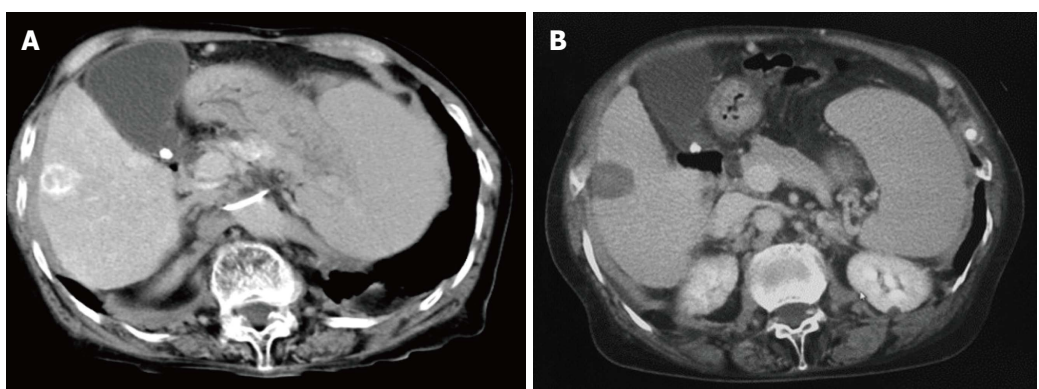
Tumors treated by radiofrequency ablation. A: Contrast-enhanced computed tomography (CT) shows hepatocellular carcinoma in segment 6 of the liver (Case 4); B: Abdominal CT image at just radiofrequency ablation shows a lesion of ablation (Case 4).
